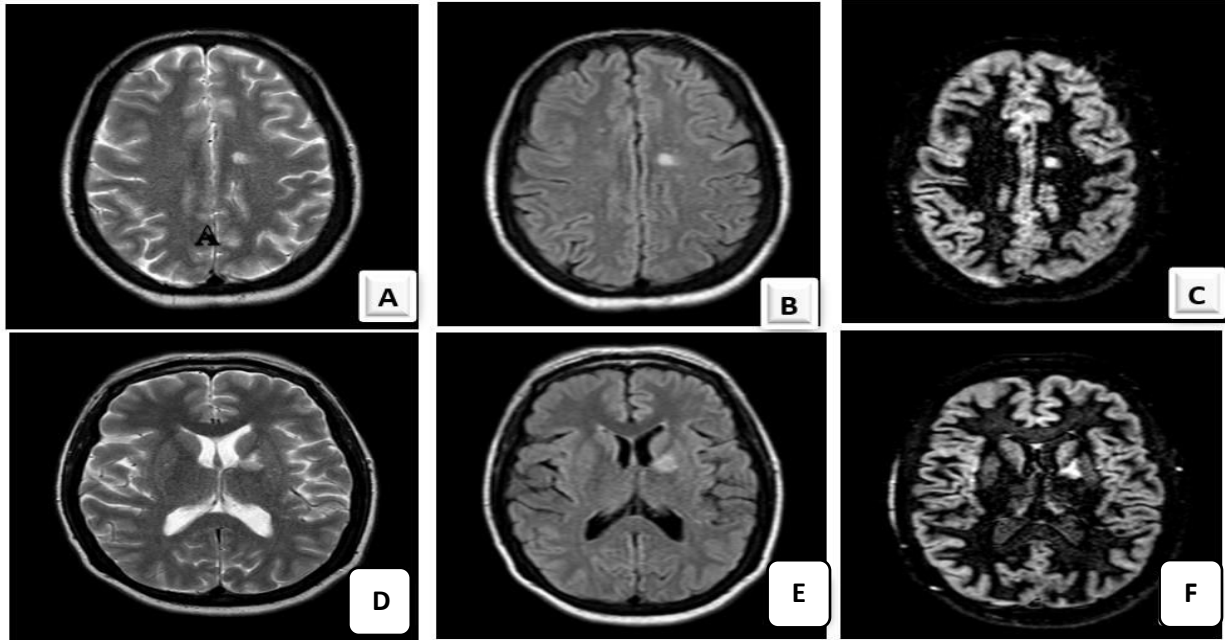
(A, D) T2, (B, E) FLAIR, and (C, F) DIR axial brain sections at multiple levels show two hyperintense lesions seen left parietal periventricular region, as well as anterior limb of left internal capsule.
